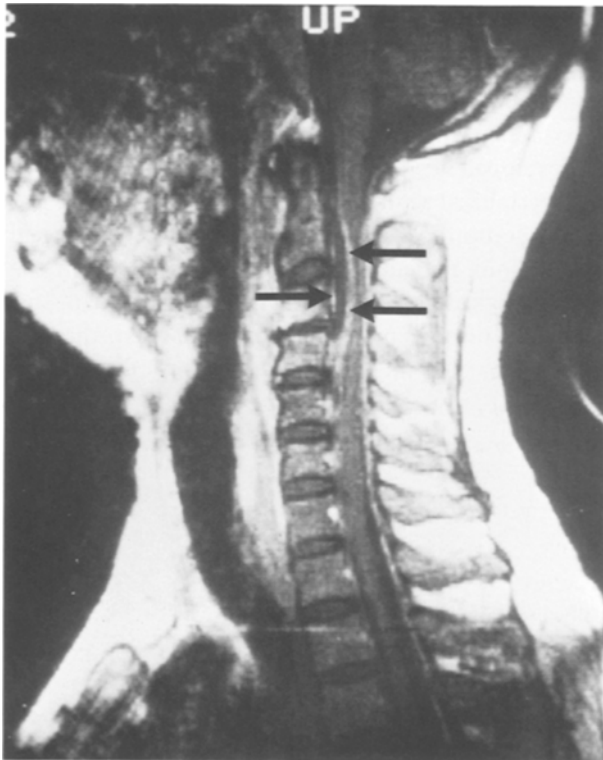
Sagittal T1-weighted, contrast-enhanced MRI (from the same patient as in Fig. 1 and Fig. 2) presenting the total extension of the epidural abscess in the upper cervical spine (arrows). The abscess membrane shows high signal intensity because of contrast enhancement
